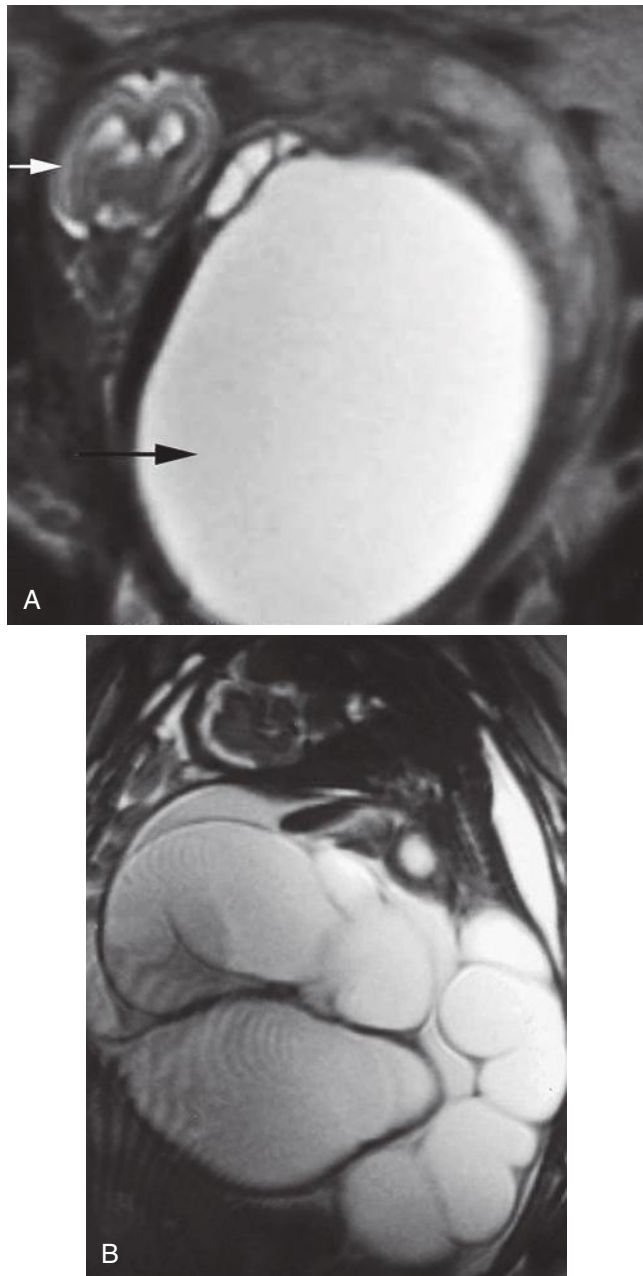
A, Sagittal T2 magnetic resonance imaging scan demonstrates high signal from a markedly dilated urinary bladder (*black arrow*). Note the size discrepancy of the fetal head (*white arrow*) at 26 weeks' gestation. B, Coronal T2 magnetic resonance imaging scan demonstrates marked dilatation of the fetal ureter. (Courtesy of Heron Werner, 2005. Available at thefetus.net.)
